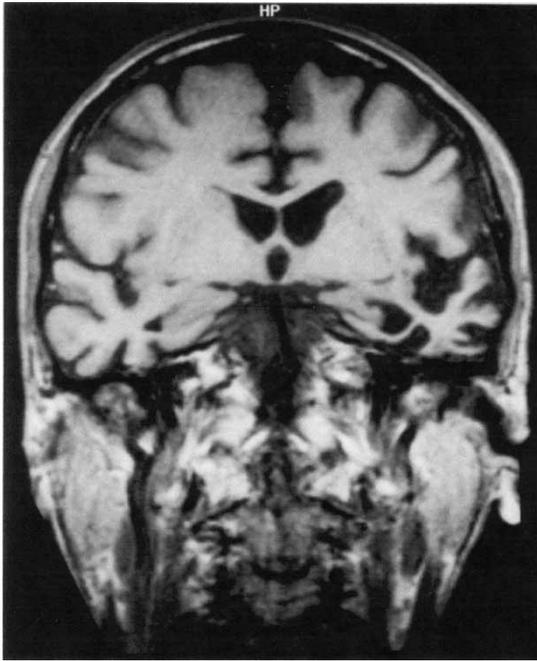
MRI scan for IH, October, 1998 showing severe left temporal lobe atrophy and only mild/moderate atrophy elsewhere in the brain including the right temporal lobe. (Note: Left is shown on right of the scan.)
